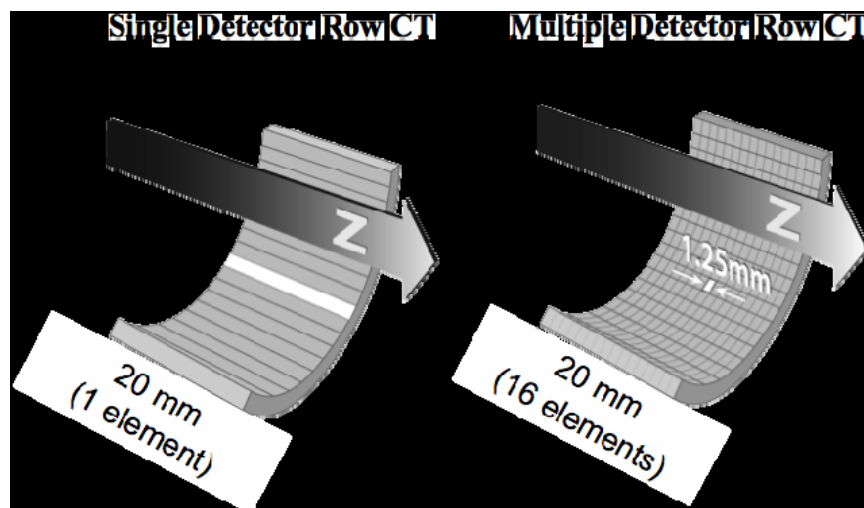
single CT detector versus Multi slice CT detector.
